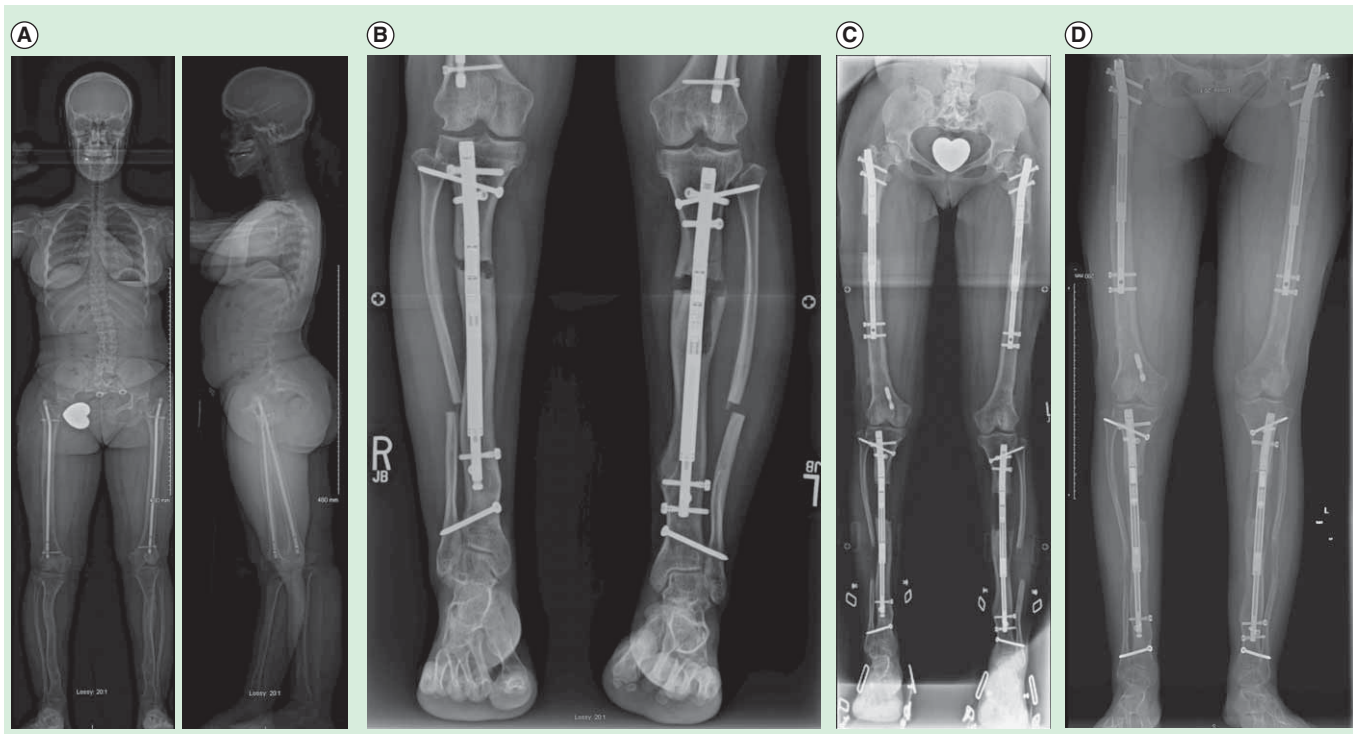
Sixteen year old girl with achondroplasia who had undergone 2 previous lower limb (combined femur and tibia 4 segment lengthening) and one bilateral humeral lengthening. (A) Preoperative standing EOS scan radiographs. (B) Bilateral tibial lengthening was carried out using Precice1 10.7mm tibial nails. (C) Two weeks later she underwent removal of the previous femoral nails and insertion of bilateral 10.7 mm Precice1 trochanteric entry nails. Both femurs were lengthened 6.5 cms and tibias 5 cms simultaneously. The staggered nail insertion was to avoid reaming all four bones at the same time because of the risk of fat embolism. (D) The patient is now 62 inches (158 cms) tall.
